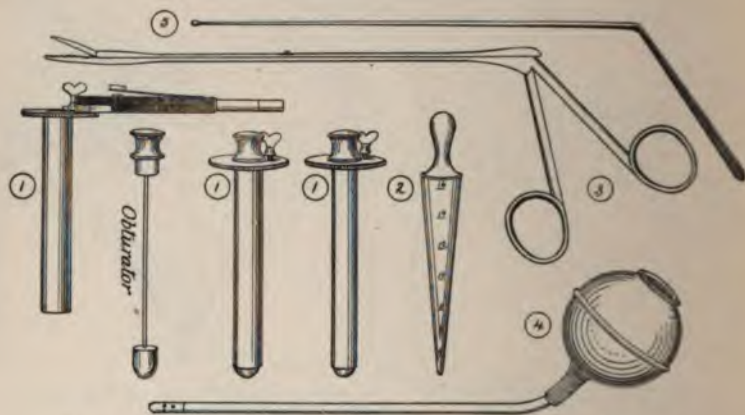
INSTRUMENTS USED FOR EXAMINING THE URETERS BY INSPECTION.
